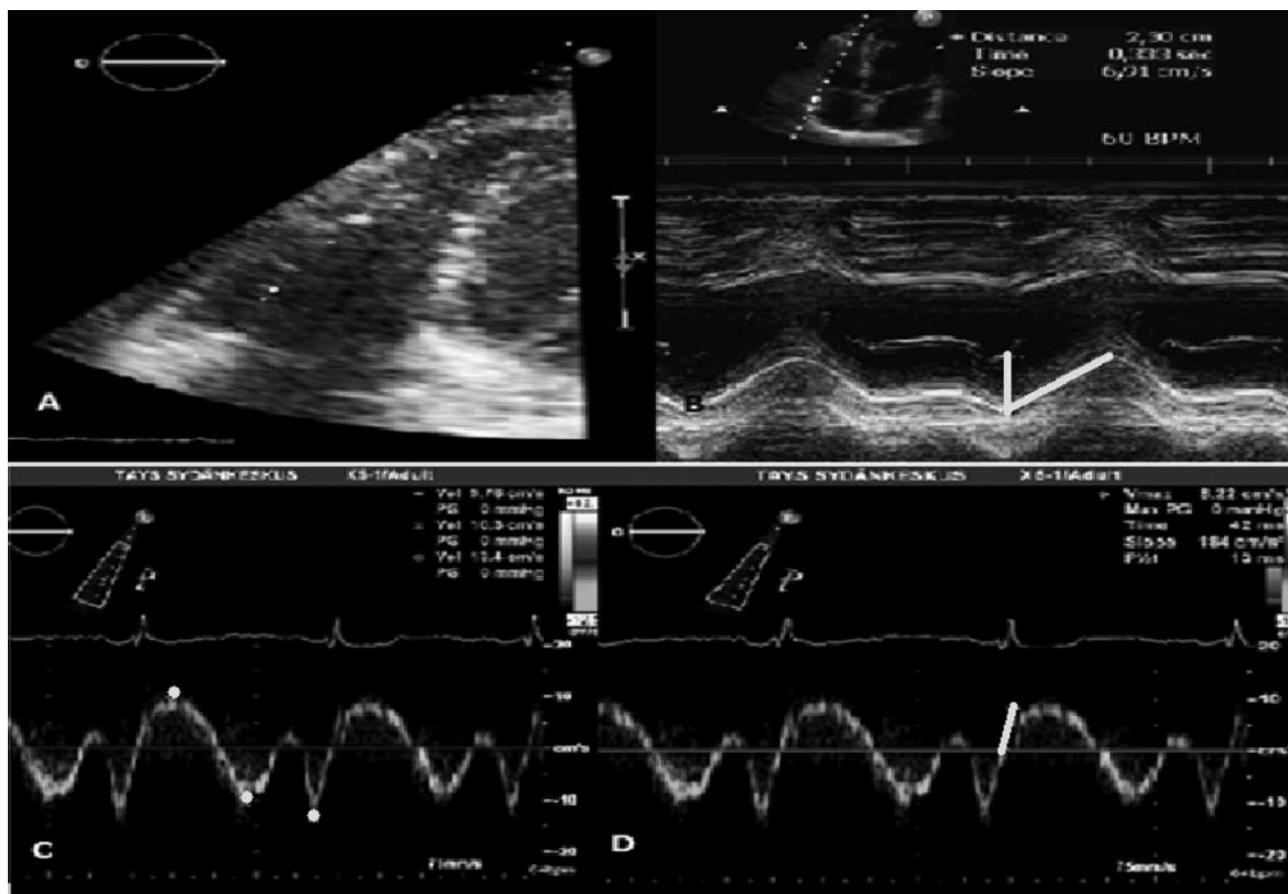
Measurements of tricuspid annular plane systolic excursion (TAPSE) and pulsed tissue Doppler velocities at the lateral RV wall. A: Focused RV image with cursor placed in the junction of RV lateral wall and tricuspid annulus. B: TAPSE measurement with M-mode. C: Measurements of peak systolic velocity (S'), peak E' velocity and peak A' velocity, respectively. D: Measurements of IVV and IVA.
